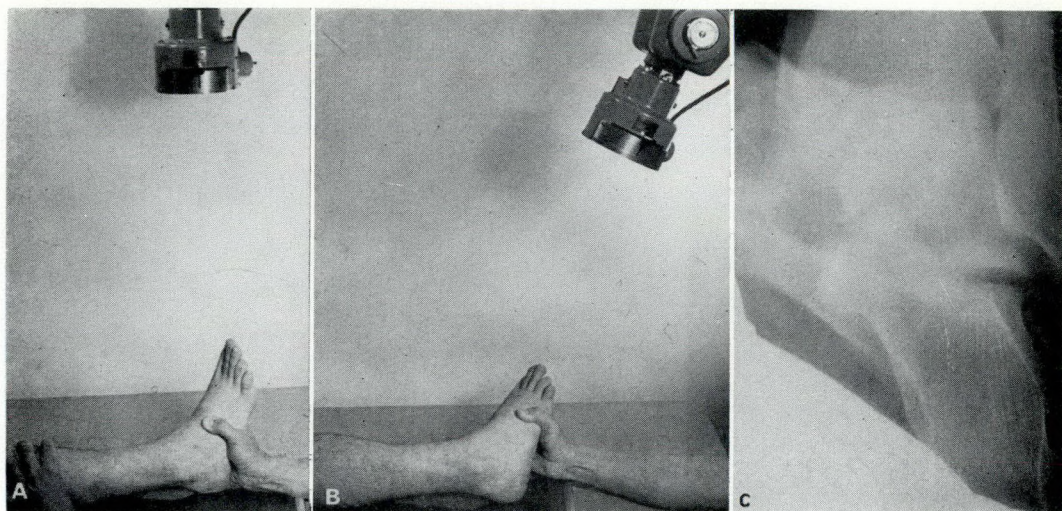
Radiographic technique for talar and subtalar tilt. (A) Anteroposterior stress film to demonstrate a talar tilt. (B) Special technique to show subtalar tilt: the x-ray tube is tilted at 45° , the leg is internally rotated 45° and a forced inversion stress is applied. (C) Normal subtalar motion using the special technique described in 10B.
